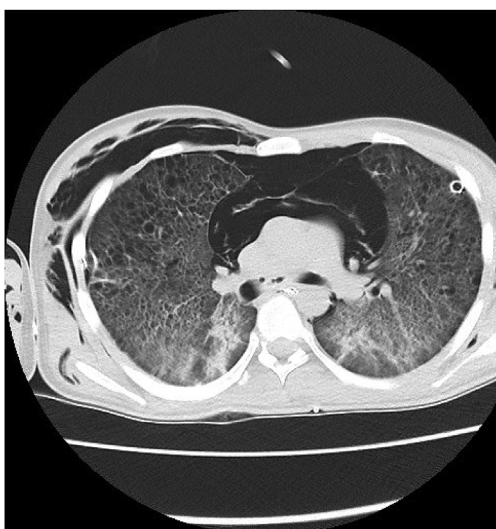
A CT scan after 18 days in the ICU. The patient developed bilateral pneumothoraces, pneumopericardium and pneumomediastinum after a transbronchial biopsy. Bilateral pleural tubes in-situ.
